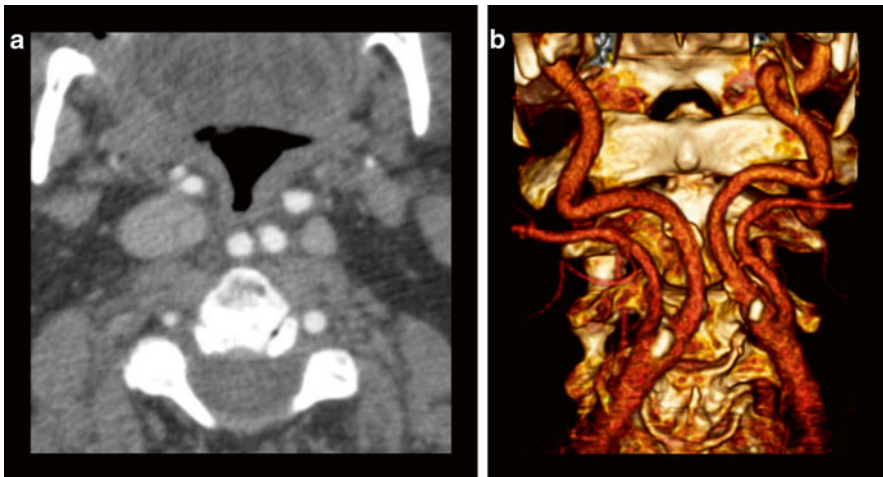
88-year-old male presenting with stroke-like symptoms. (a) Axial CTA image reveals “kissing” internal carotid arteries (*arrow*) which lie in a retropharyngeal location. (b) 3D volume rendering better displays the abnormal medial orientation of the carotids
